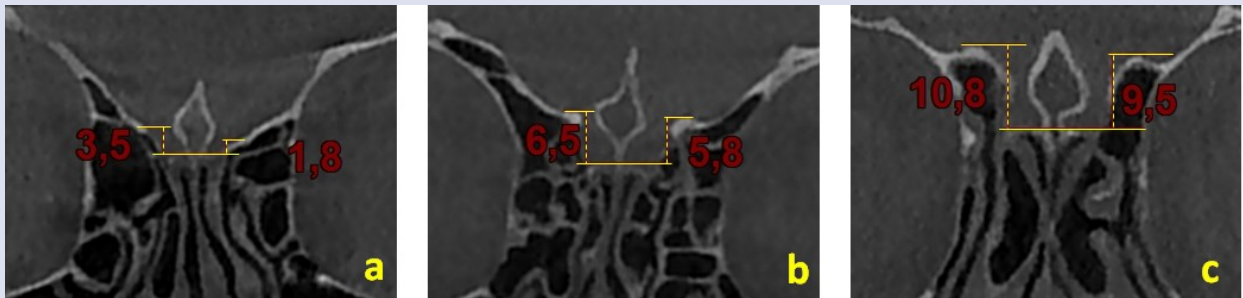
Keros classification types of the CG on coronal CBCT slices. a) Keros type 1. b) Keros type 2. c) Keros type 3.
